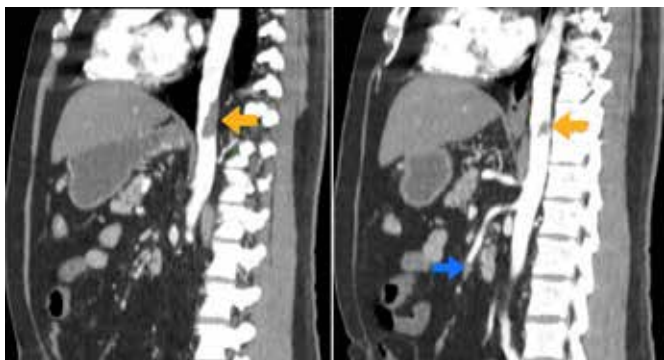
Contrast-enhanced Computed Tomography of the abdomen in the arterial phase - Yellow arrows indicating thrombus located in the distal portion of the thoracic aorta and blue arrow, occlusion point of the superior mesenteric artery.
